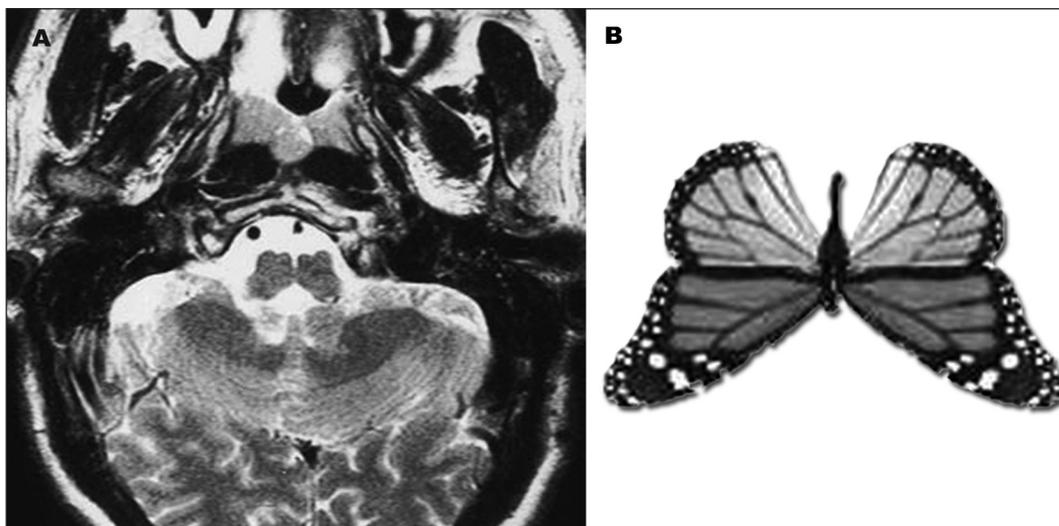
T2-weighted brain MRI, axial view. Dysplastic and atrophic medulla with a particularly pronounced ventral sulcus [A]. The olives are prominent as compared to the pyramids, giving a pareidolic aspect of a butterfly to the brainstem [B].
